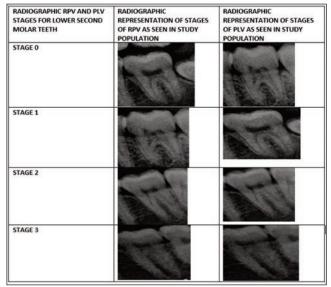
Radiographic representation of stage classification of radiographic root pulp visibility and periodontal ligament visibility in lower second molar teeth.
